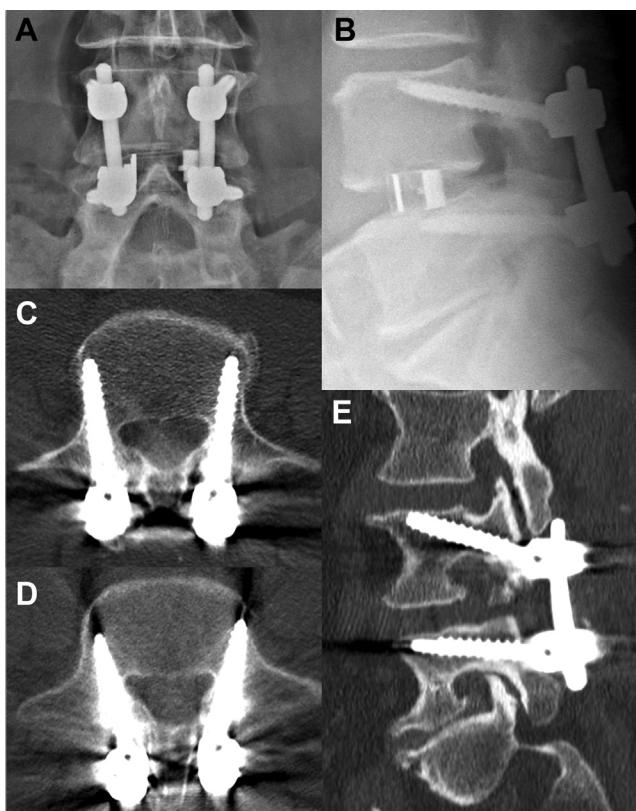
Postoperative radiographs of an L4-L5 transforaminal lumbar interbody fusion performed with cortical bone trajectory screws (A, B). The most high-density bone is reached through the divergent and caudocephalad path of the screws as shown on a postoperative computed tomography scan (C-E).
